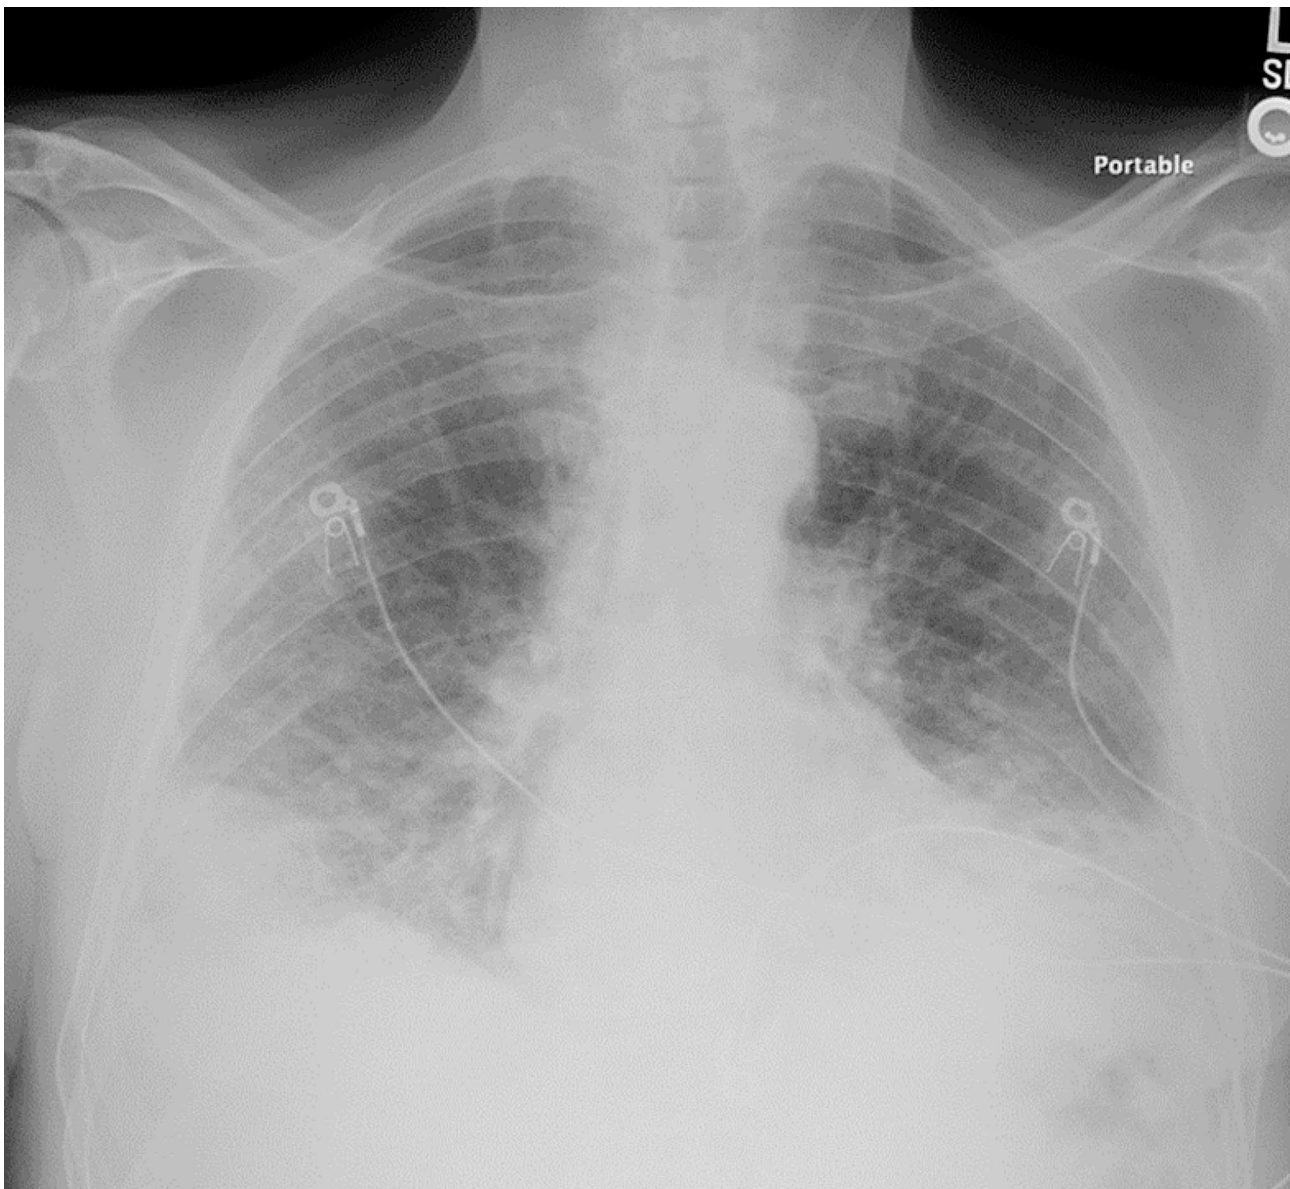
Portable chest radiograph of index case obtained on hospital admission. Bilateral mid and lower lung interstitial and airspace opacities. Right hemidiaphragm elevation with lateral lobulated contour stable when compared to previous chest imaging (not shown)
